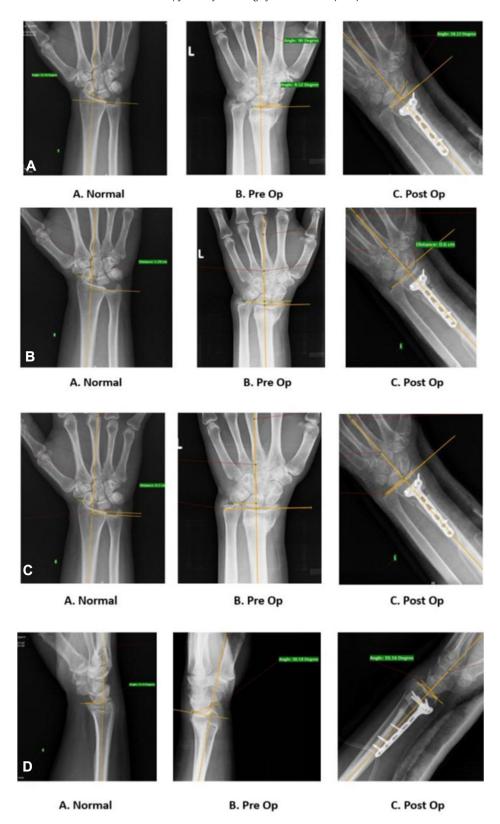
A Radial inclination. B Radial height. C Ulnar variance measured on posteroanterior radiograph. D Dorsal/volar tilt measured on a lateral radiograph.
